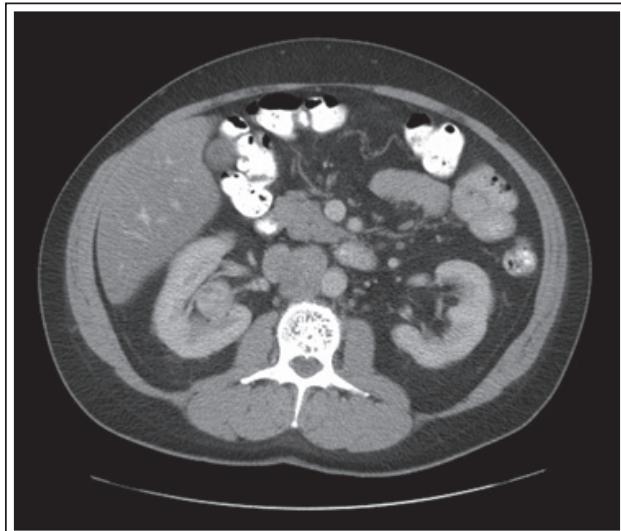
Computed tomography with intravenous contrast showing a centrally located right renal mass and interaortocaval lymphadenopathy.
